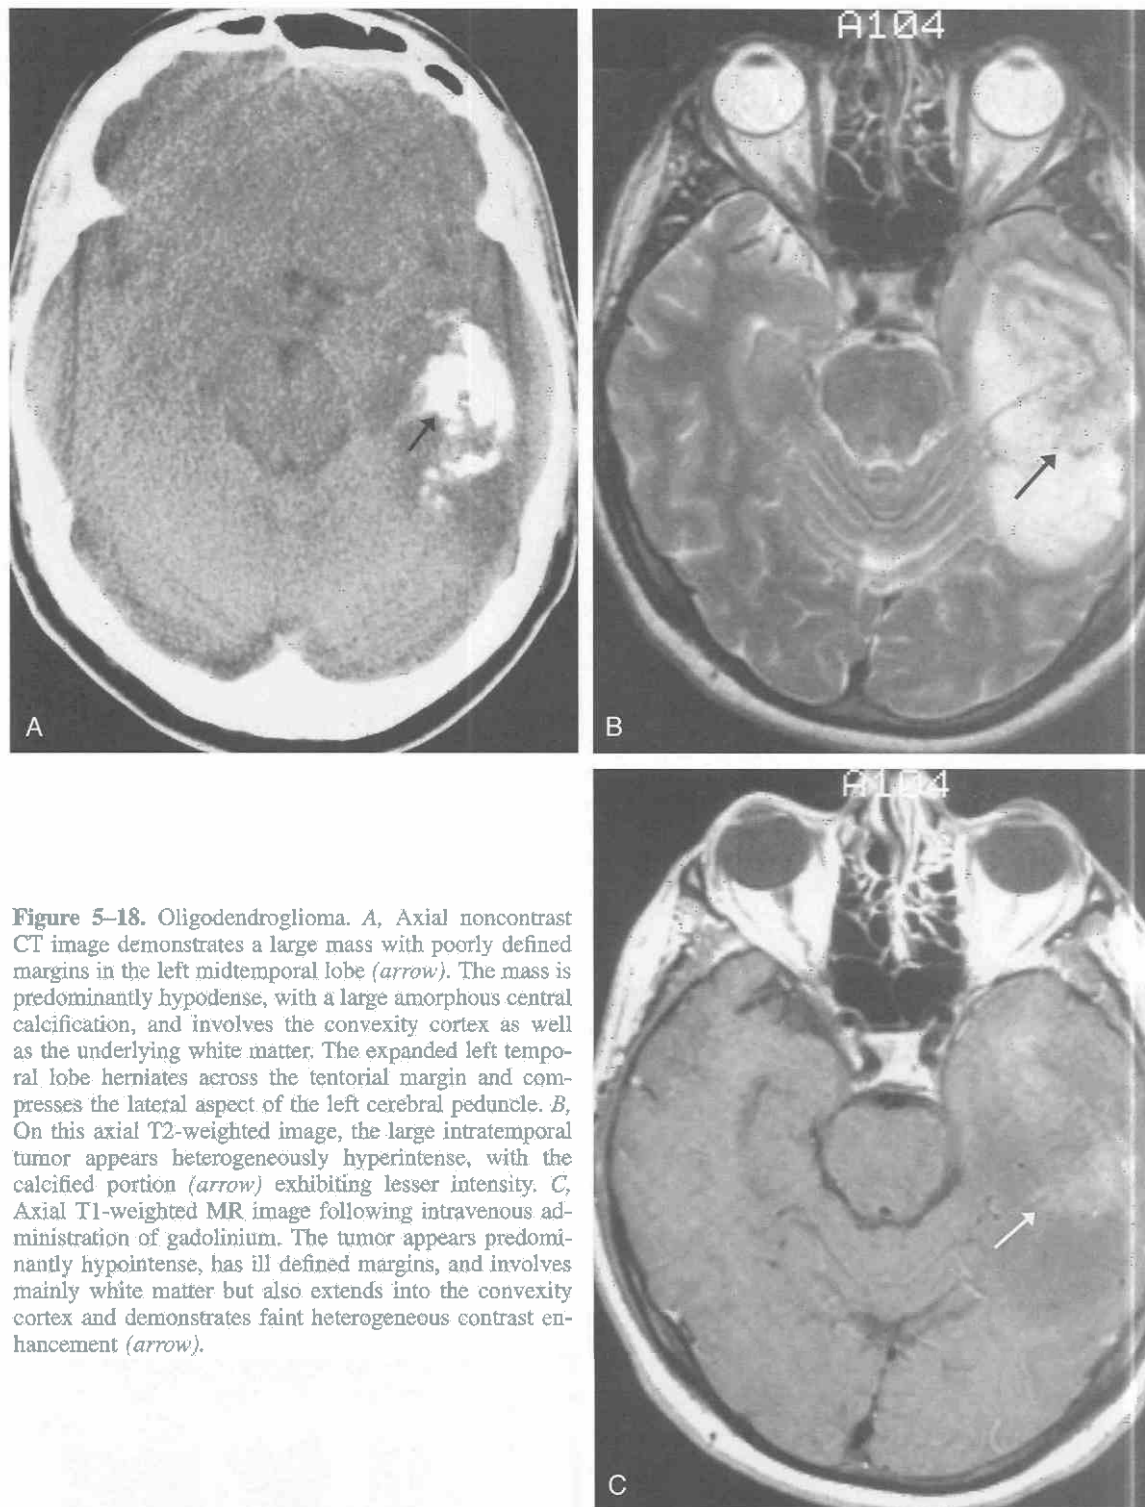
Oligodendroglioma. *A*, Axial noncontrast CT image demonstrates a large mass with poorly defined margins in the left midtemporal lobe (*arrow*). The mass is predominantly hypodense, with a large amorphous central calcification, and involves the convexity cortex as well as the underlying white matter. The expanded left temporal lobe herniates across the tentorial margin and compresses the lateral aspect of the left cerebral peduncle. *B*, On this axial T2-weighted image, the large intratemporal tumor appears heterogeneously hyperintense, with the calcified portion (*arrow*) exhibiting lesser intensity. *C*, Axial T1-weighted MR image following intravenous administration of gadolinium. The tumor appears predominantly hypointense, has ill defined margins, and involves mainly white matter but also extends into the convexity cortex and demonstrates faint heterogeneous contrast enhancement (*arrow*).
